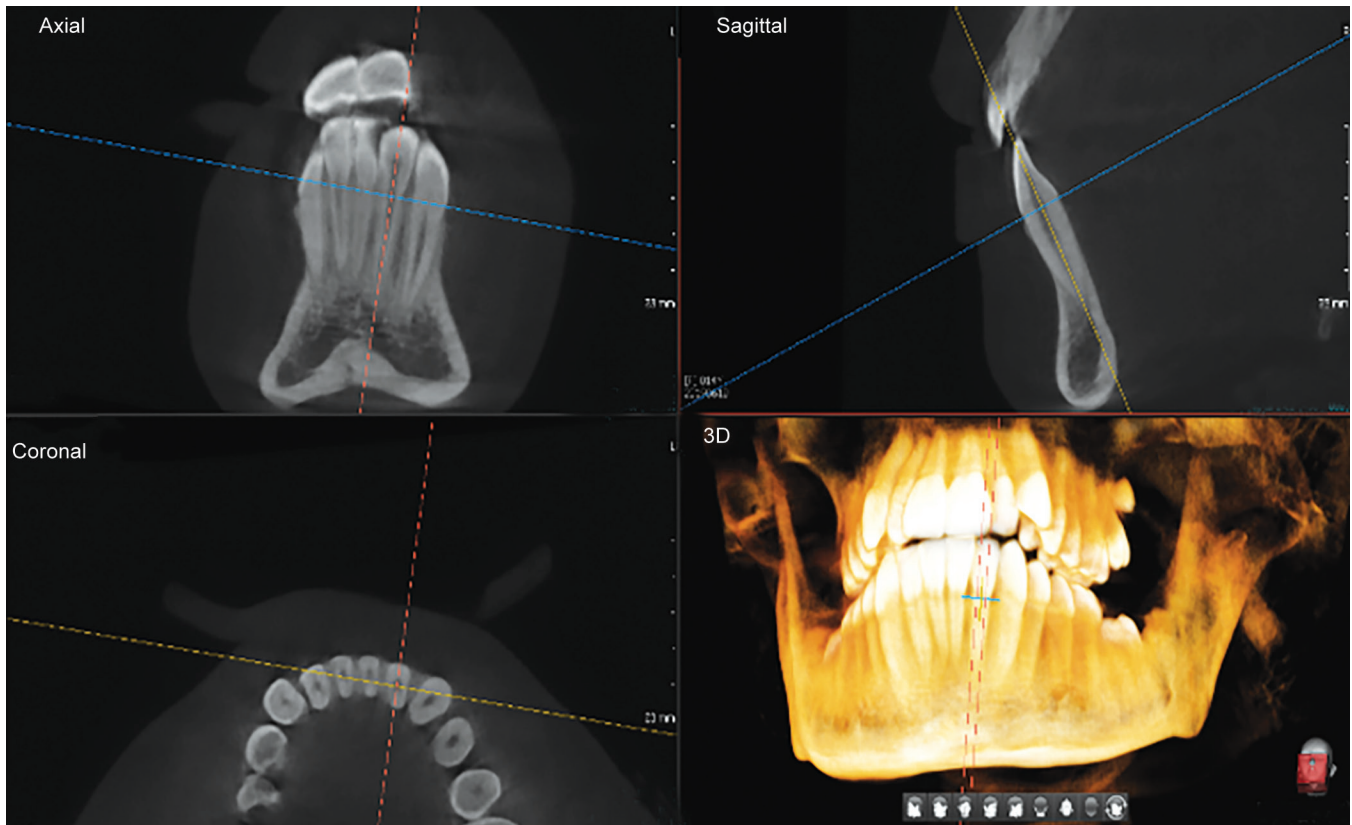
Construction of multiplanar windows of the CBCT-based length measurements
